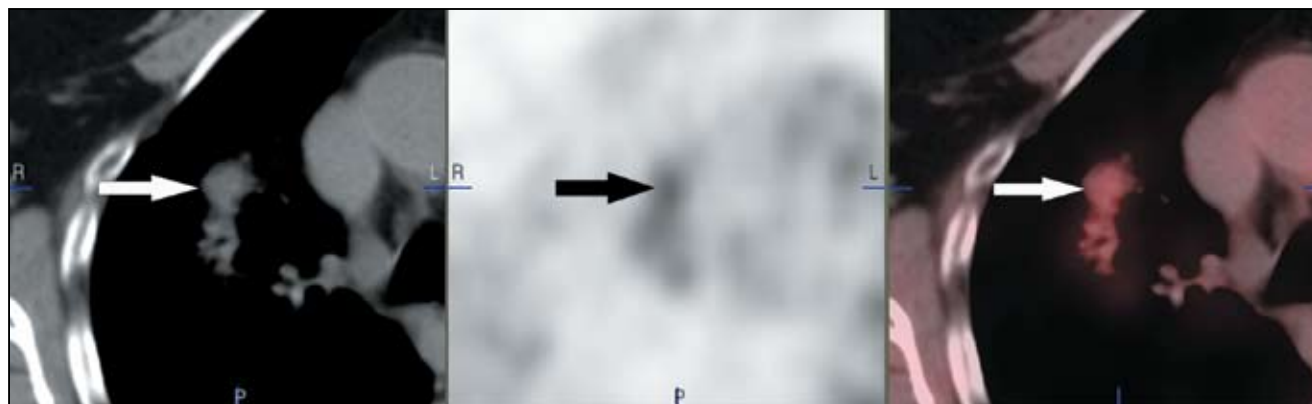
Axial CT (A), PET (B), and fused PET/CT (C) performed 6 months after RFA images show curvilinear activity around the ablation site with slightly more intense activity anteriorly (arrows).
